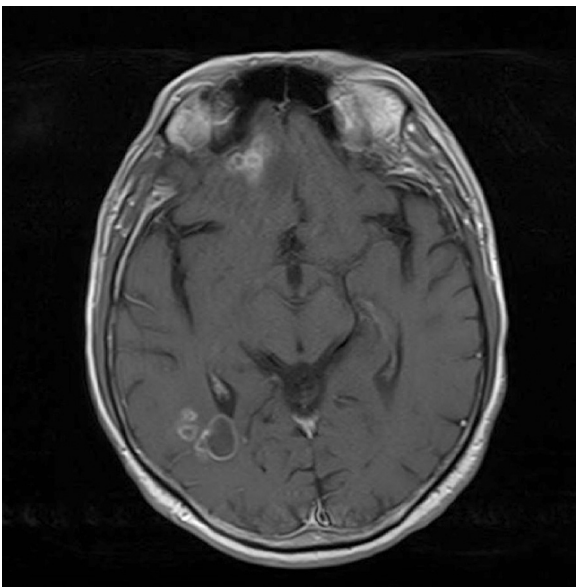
Coronal CT scan of the brain with contrast six weeks after initial presentation. There is an interval increase in the number and size of the lesions with surrounding vasogenic edema.
